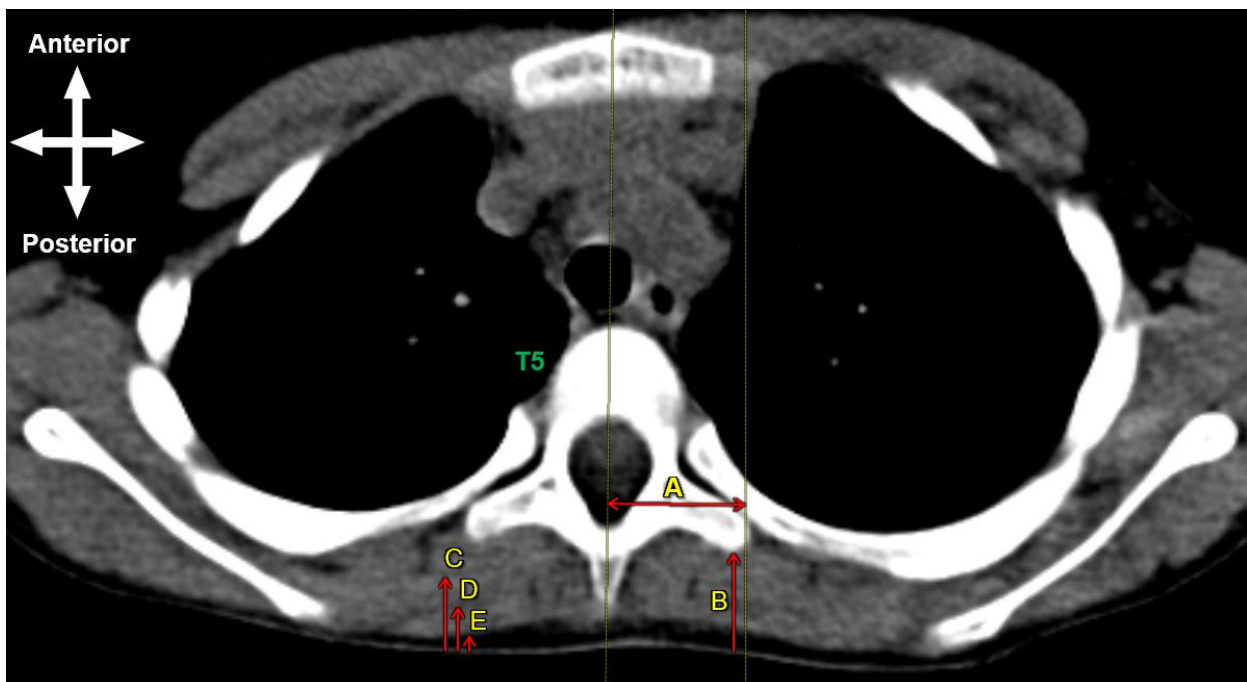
An axial CT image through the thorax at vertebral level T5. Measurements that were taken include; A – the distance from the spinous process to the lateral extent of the transverse process; B – the depth from the skin to the ESFP space (tip of the transverse process); C – the depth from the skin to the most superficial point of the erector spinae muscle; D – the depth from the skin to the most superficial point of the rhomboid major muscle; E – the depth from the skin to the most superficial point of the trapezius muscle.
